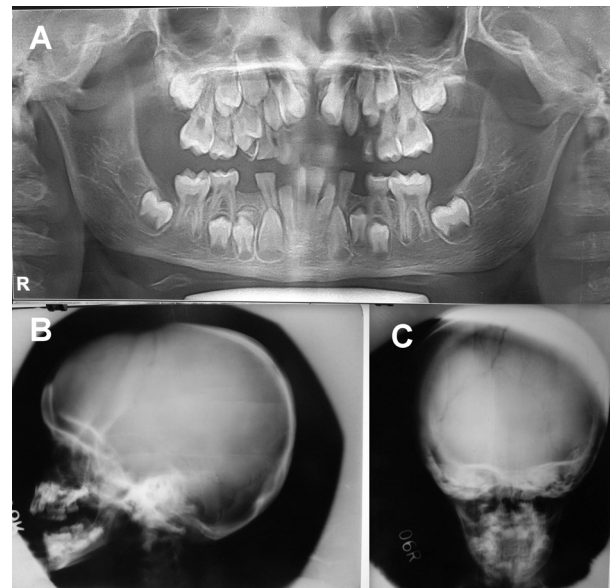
Radiographs showing dental abnormalities (A), Retained primary teeth and supernumerary teeth seen on OPG. (B) and (C) Cranial abnormalities such as open fontanelles, sunken sutures, wormian bones seen on lateral view and anteroposterior view of skull.
